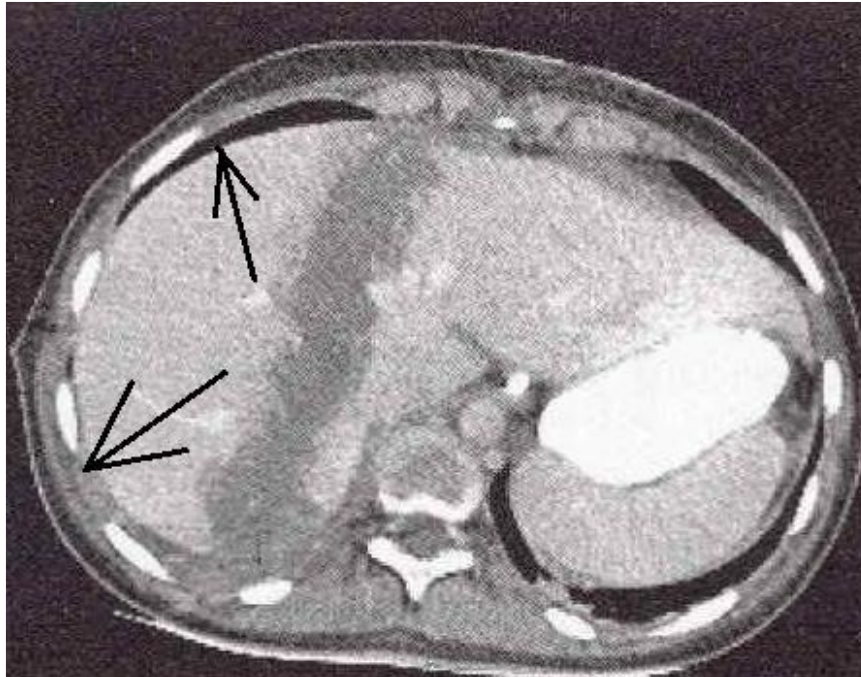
CT scan of abdominal organs, axial projection. Penetrating gunshot wound to the abdominal cavity, hemopneumoperitoneum (arrows).
